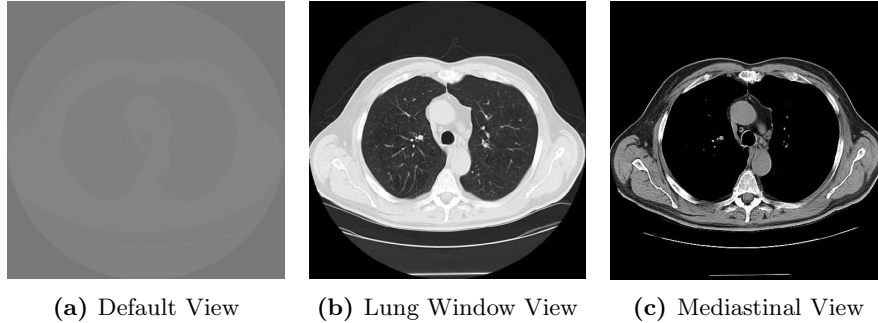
Different Chest CT views based on window parameter adjustments.
